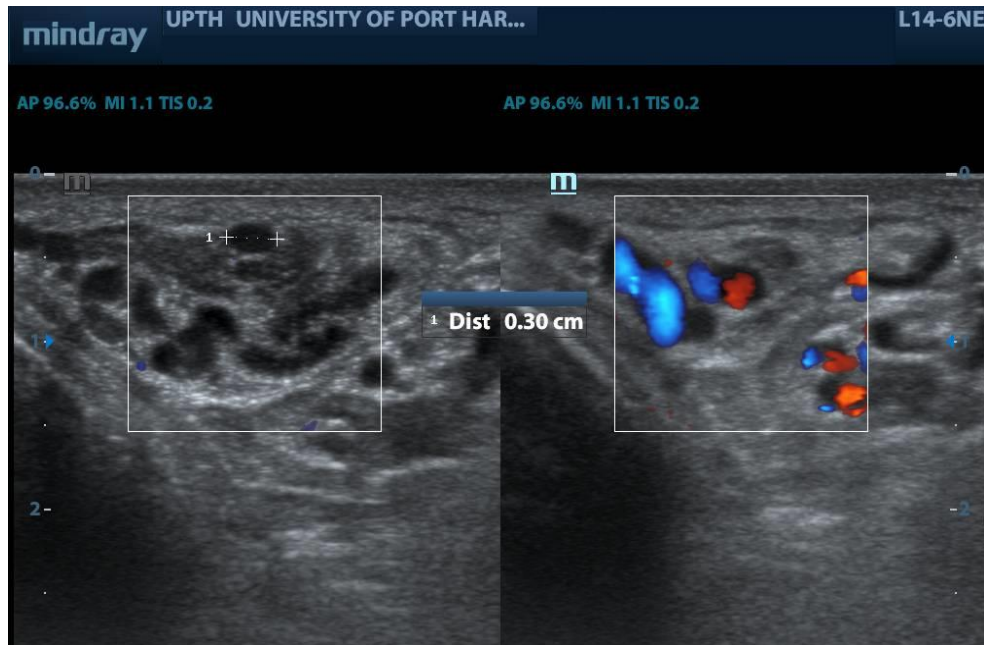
Varicocele. Colour Doppler sonogram showing dilated veins of the pampiniform plexus measuring 3 mm in diameter
